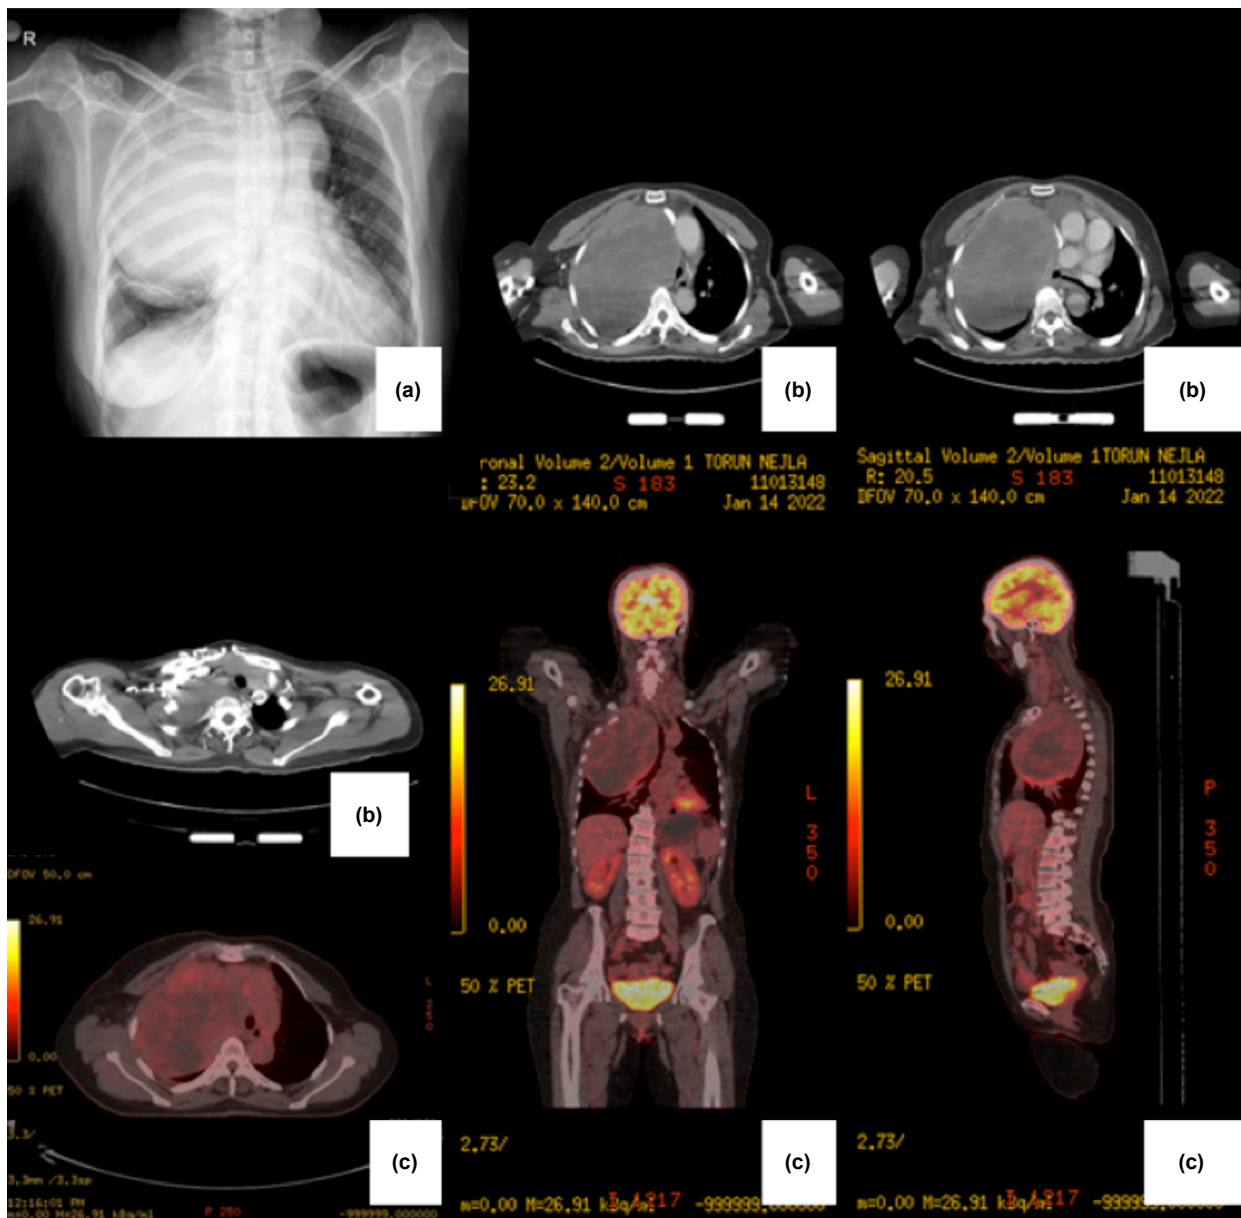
Preoperative radiological evaluation of the patient: (a) Chest X-ray, (b) axial images in computed tomography, and (c) axial, coronal, and sagittal images in positron emission tomography.
